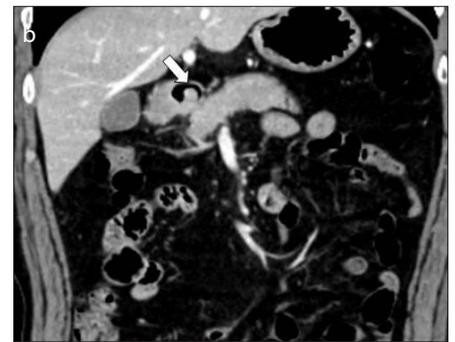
a, b. CT image in a 46-year-old man with Brunner gland adenoma. Portal phase axial (*a*) and coronal (*b*) CT images show a 1.6 cm endoluminal protruding mass (*arrow*) in the duodenal bulb with homogeneous enhancement. It was proven to be a Brunner gland adenoma in biopsy.
